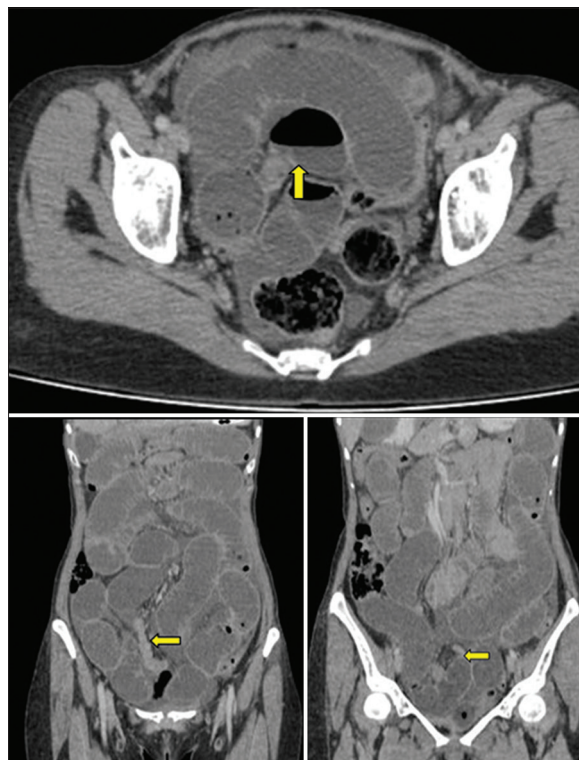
Multidetector computed tomography enteroclysis-enteroclysis in a 49-year-old female patient showed dilated small bowel loops with a transition point at approximately 15 cm from the ileocecal junction with the collapse of the distal ileal loop
